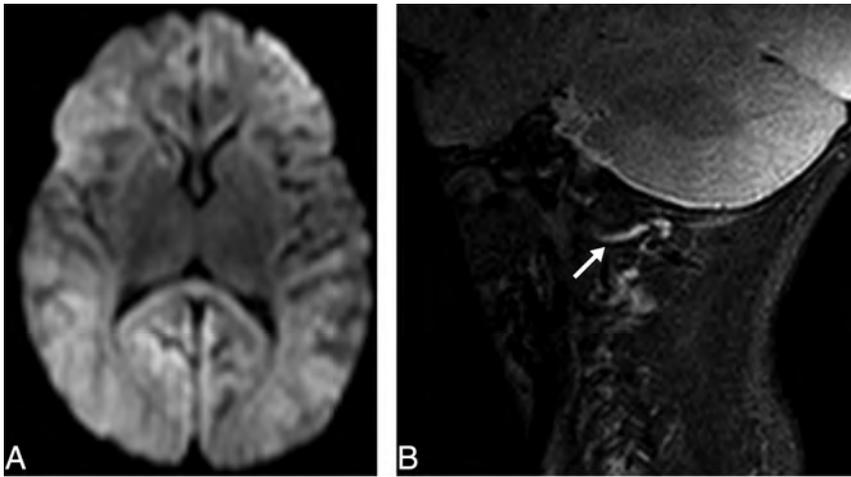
Two-month-old patient. A, Axial trace DWI shows diffuse restricted diffusion involving the bilateral cerebral hemispheres. B, Sagittal paramidline STIR image shows abnormal fluid within the atlanto-occipital joint space with mild distension (arrow), consistent with capsular injury.
